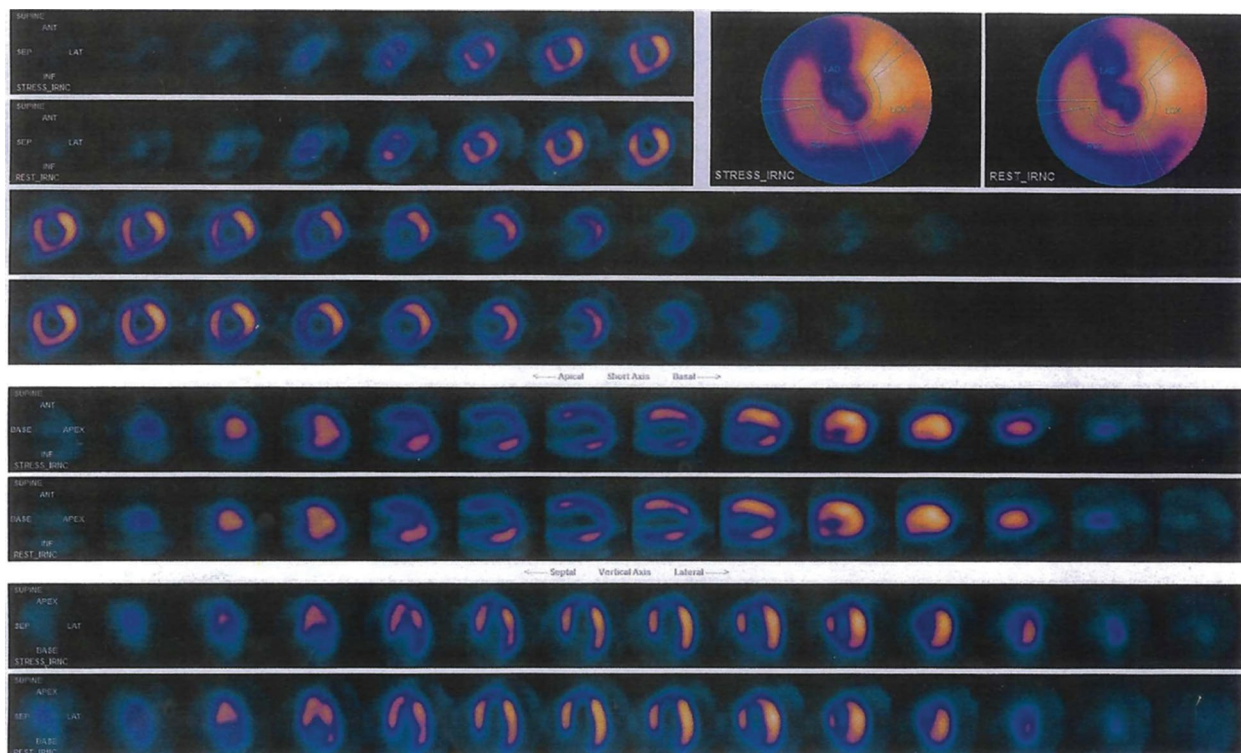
Result of perfusion scintigraphy of the heart conducted in 2019
